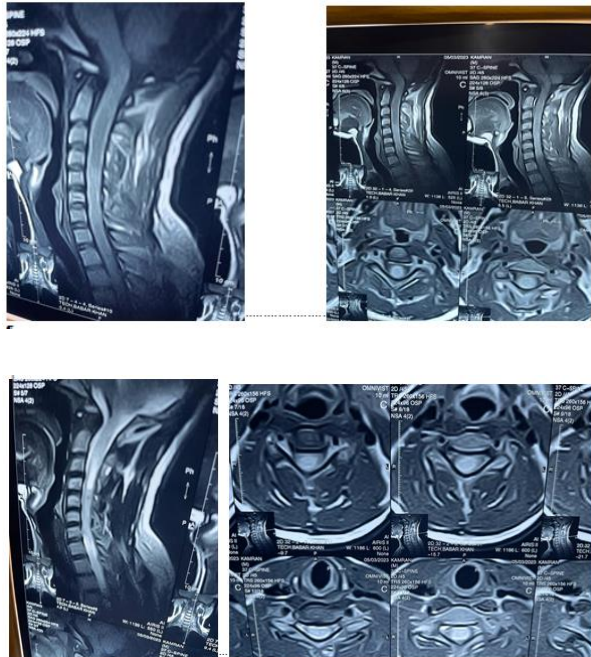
MRI-based radiological characteristics of IMSCTs
